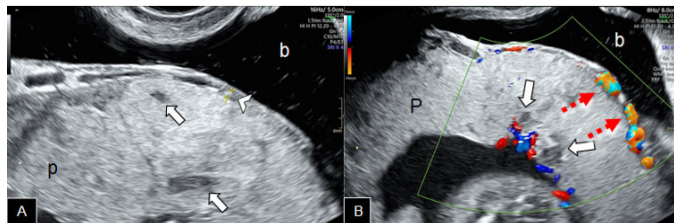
(A, B) Obstetric ultrasound images, in gray scale (A) and color Doppler (B). Placental lacunae (arrows), thinning of the prevesical myometrium demarcated with yellow crosses (arrowhead in A) are observed. Also vascular structures are depicted in direct relation to the bladder wall (dashed red arrows in B). p: placenta; b: bladder.
